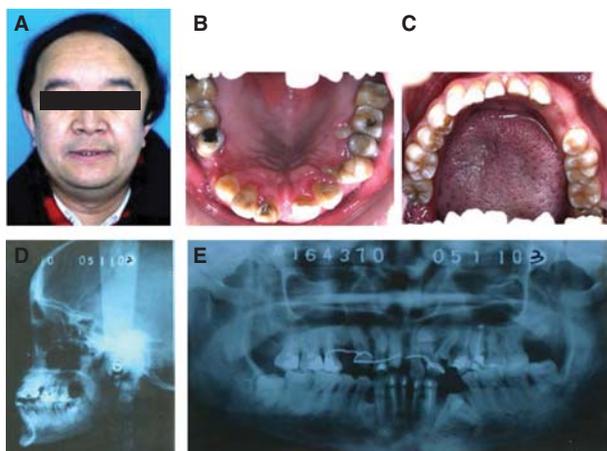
Patient 15 had CCD with four supernumerary teeth (three in the maxilla in the area of the premolars and one in the mandible in the area of the premolars) and three impacted teeth (one in the maxilla in the area of the premolars and two in the mandible in the area of the premolars): (A) Photograph of the patient showing ocular hypertelorism. (B) Photograph of erupted supernumerary teeth in the maxilla. (C) Photograph of the mandible. (D) Skull radiograph showing deformity of the skull, hypoplastic midface and supernumerary teeth. (E) Dental panoramic radiograph, confirming the diagnosis.
